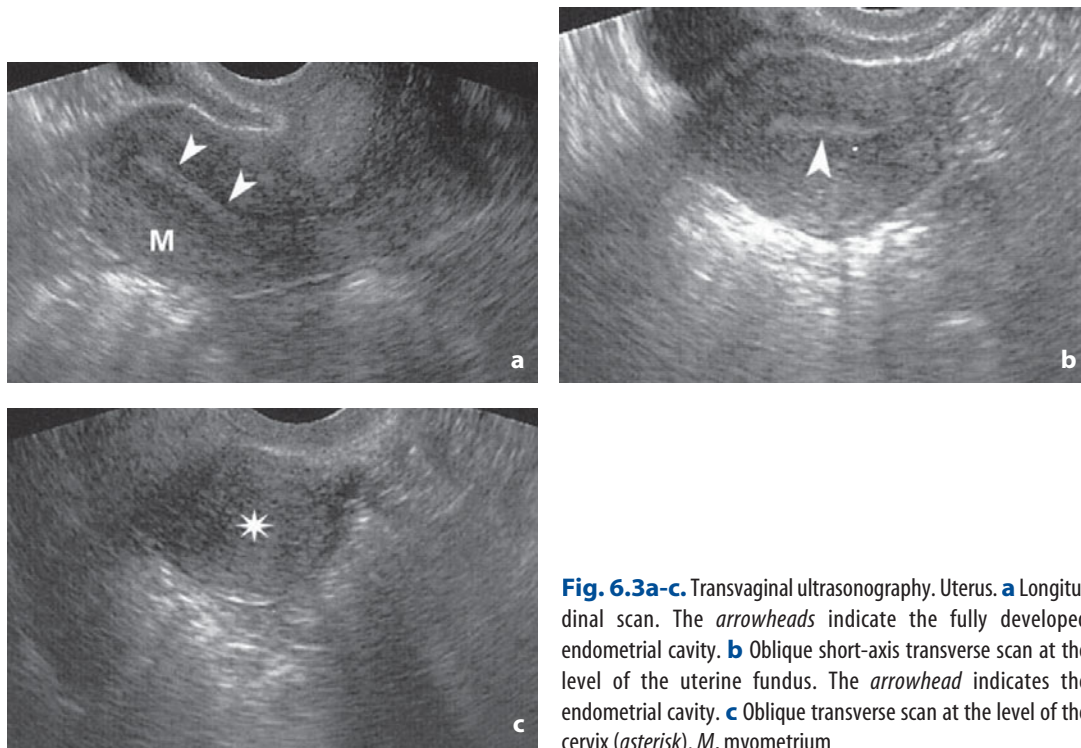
Transvaginal ultrasonography. Uterus. a Longitudinal scan. The *arrowheads* indicate the fully developed endometrial cavity. b Oblique short-axis transverse scan at the level of the uterine fundus. The *arrowhead* indicates the endometrial cavity. c Oblique transverse scan at the level of the cervix (*asterisk*). *M*, myometrium
